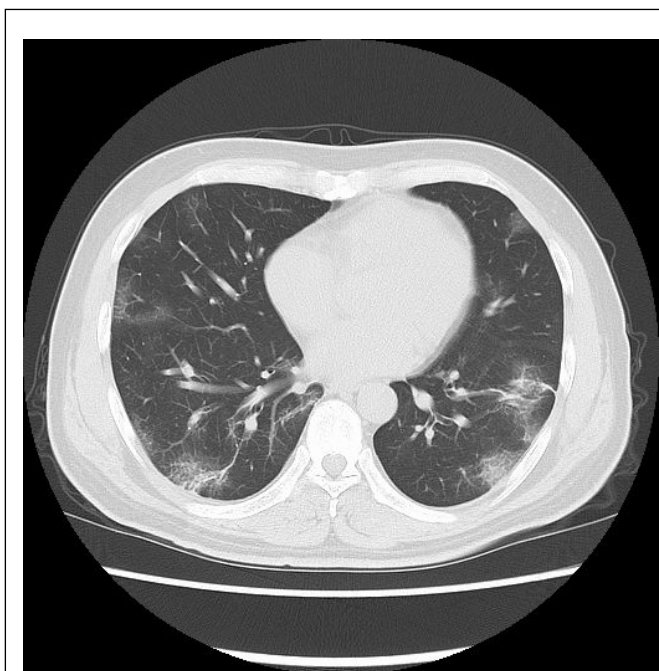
COVID-19 patient chest CT.
